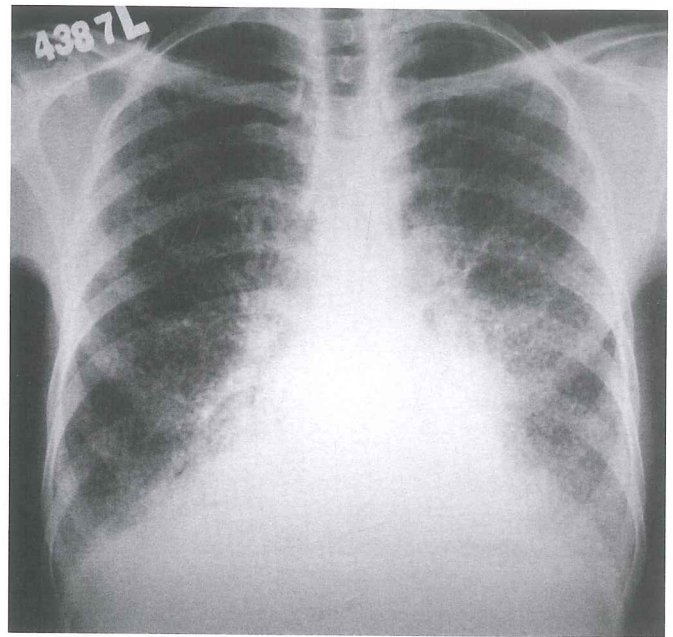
Chest x-ray of index patient's brother
